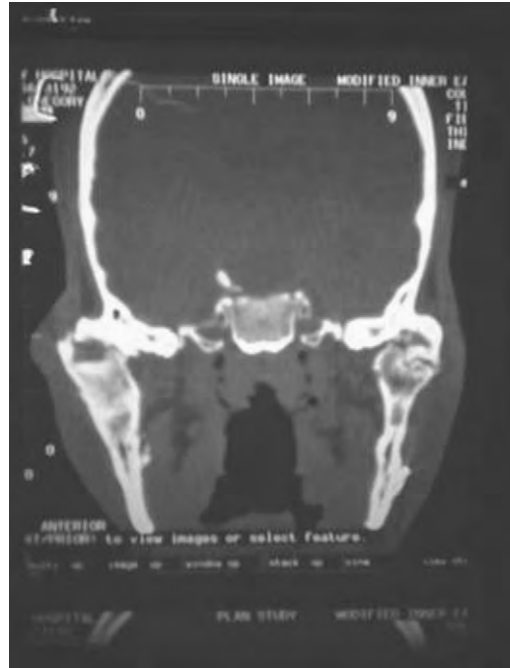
CT Scan of bilateral temporomandibular joint ankylosis.
